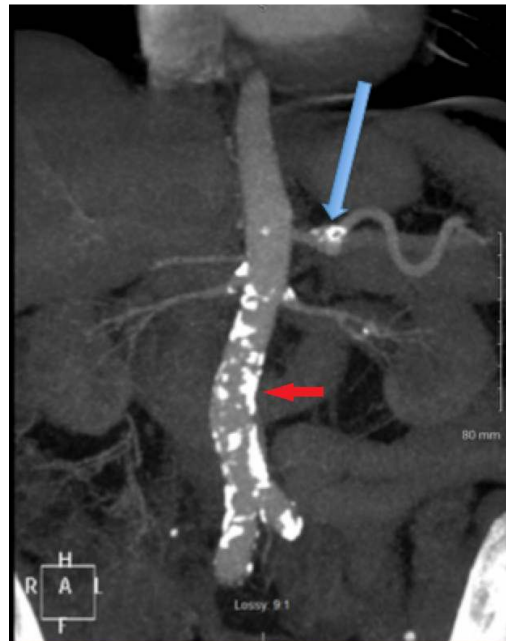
CT angiography of dissecting aneurysm within the celiac axis. Red arrow indicated bright calcium signal in abdominal aorta, celiac and iliac arteries. This signal indicates the presence of atherosclerosis, which is the independent predictor of adverse cardiovascular events such as stroke and coronary artery disease [H]
